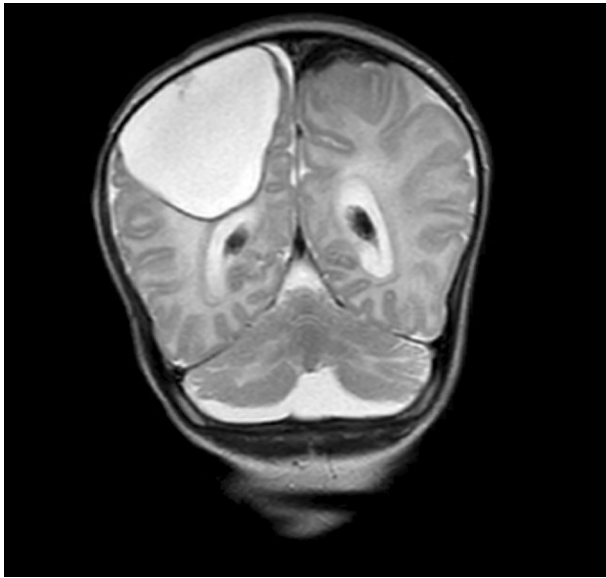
Magnetic resonance imaging scan. T2 weighted frontal image showing a large porencephalic cyst on the right side and subarachnoid left and intraventricular bleeding on both sides.
